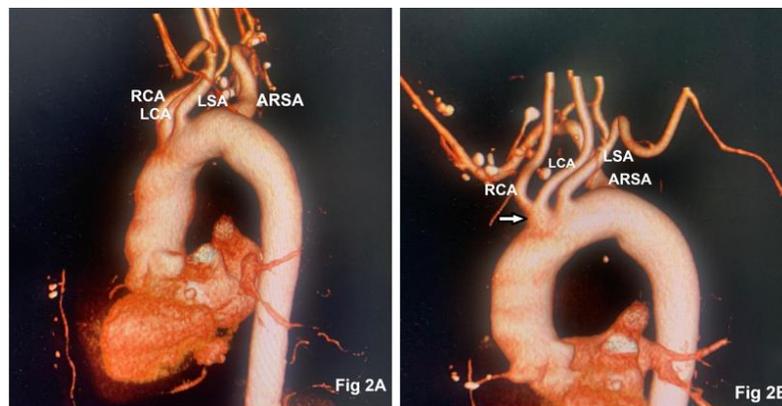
Digital reconstruction of axial computed tomography depicting RCA (right carotid artery), LCA (left carotid artery), LSA (left subclavian artery), and ARSA (aberrant right subclavian artery, Fig 2A). Combined origin of RCA and LCA (arrow) from the aortic arch (Fig 2B)
